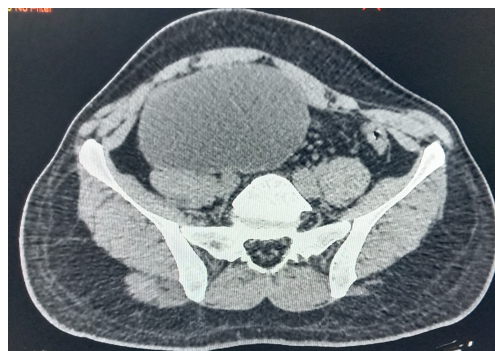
CT Abdomen showing the presence of mesenteric cyst
